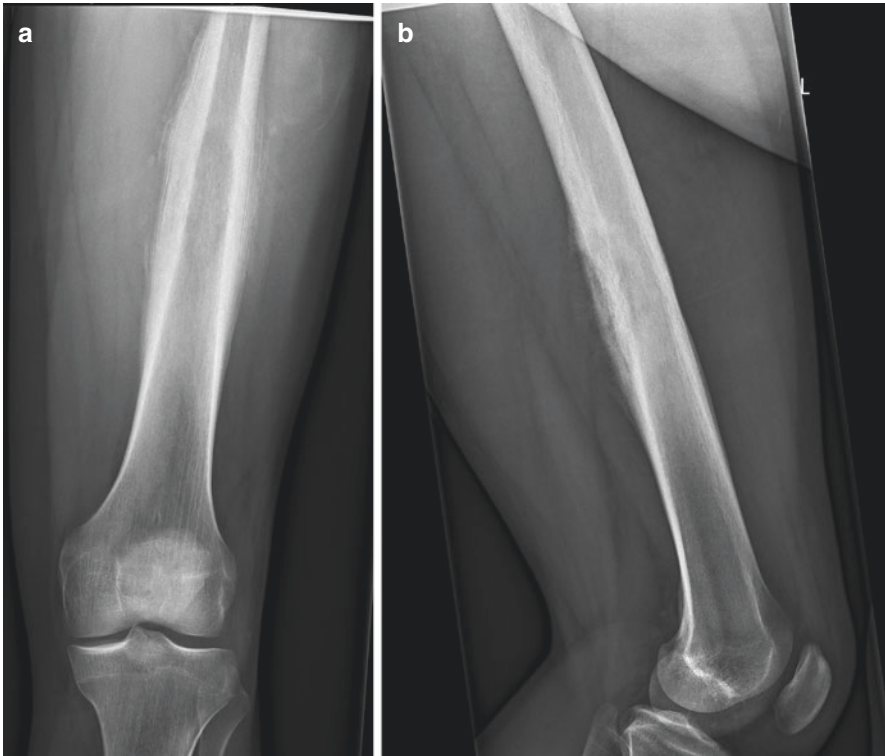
(a) Anteroposterior and (b) lateral plain radiographs of the left femur in a 19-year-old male with a lamellated or onion-skin appearance of a distal left thigh Ewing's sarcoma. Note the large associated soft tissue mass with rim-mineralisation proximally and a Codman's triangle of aggressive periosteal reaction on the lateral view
